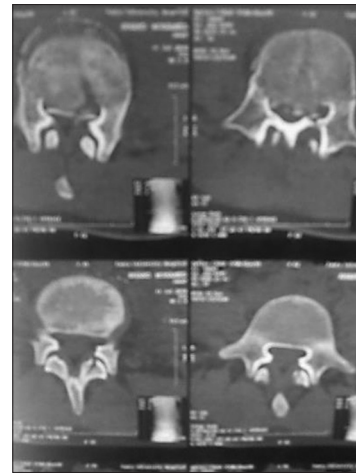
Axial computed tomography showing L4 burst fracture with retropulsed fragment
